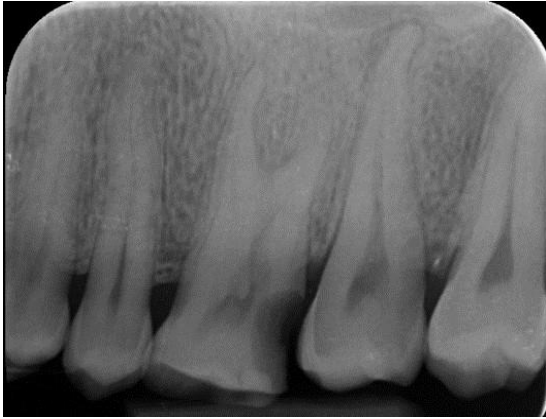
Pretreatment periapical radiograph of upper left first taurodontic molar shows deep disto-occlusal caries
